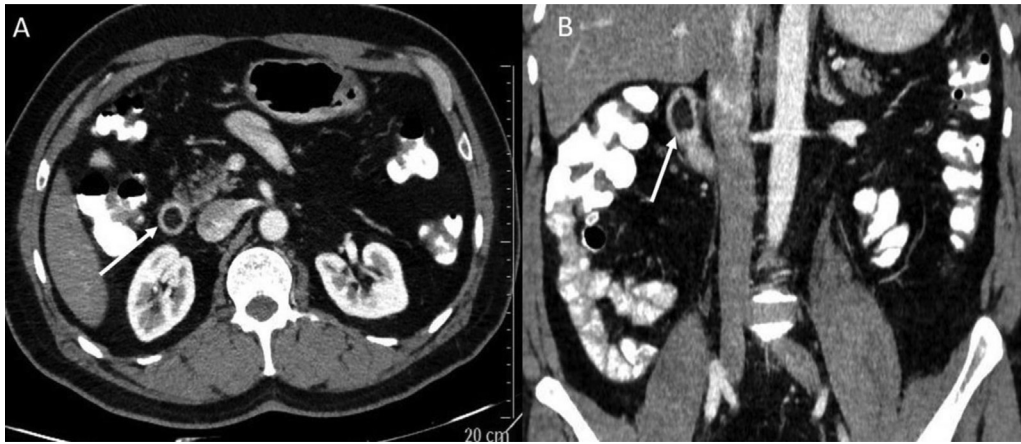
Lipoma: Axial (A) and coronal sections (B) of contrast-enhanced computed tomography abdomen showing a well-defined fat attenuation lesion in second part of duodenum (white arrows).
